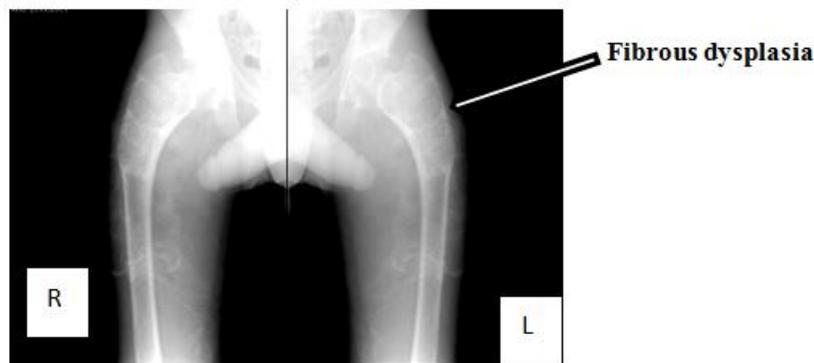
Image for both hip joints & upper femurs x-rays show fibrous dysplasia (arrow).
